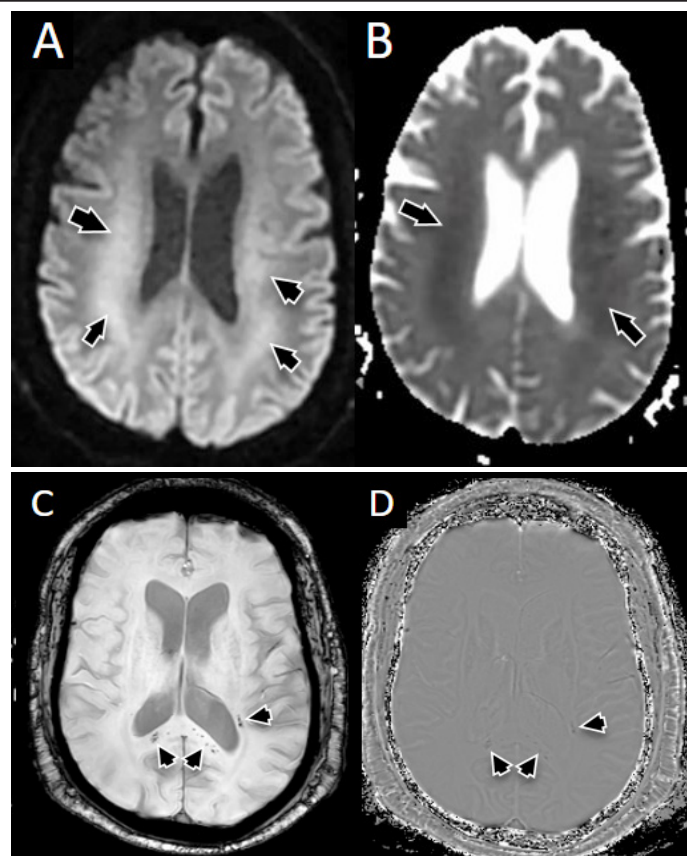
One week follow up MRI (A, B): Axial DWI (A) and ADC map showed areas of restricted diffusion within periventricular and deep white matter of bilateral frontal and parietal lobes (black arrows). 2-week follow up MRI (C,D): Axial SWI (C) and phase (D) showed the new areas of microhemorrhages within the splenium of corpus callosum and left peritriangular white matter (black arrowheads).
